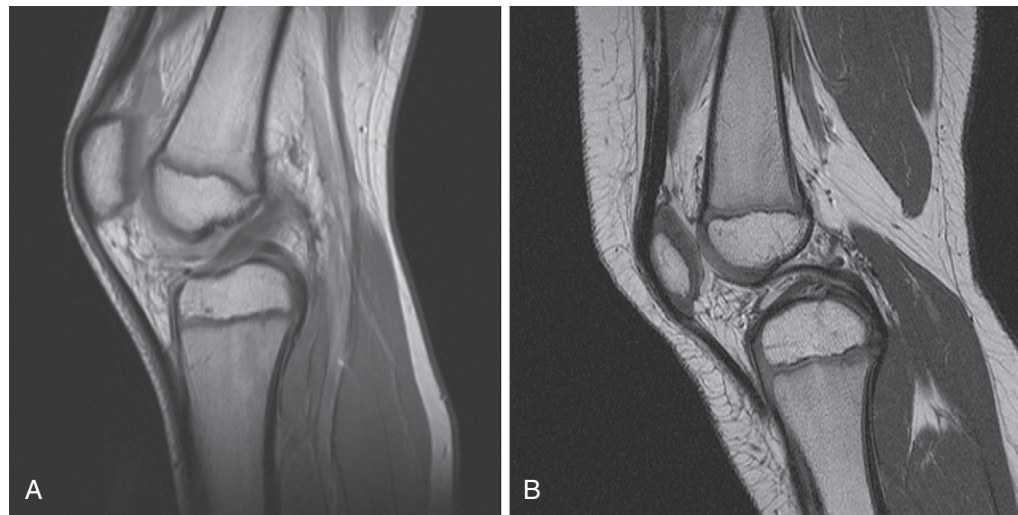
Comparison of image quality between 1.5 T (A) and 3.0 T (B). (From MacKenzie JD, Vasanawala SS: *Advances in pediatric MR imaging*. *Magn Reson Imaging Clin N Am* 2008;16:385–402.)
